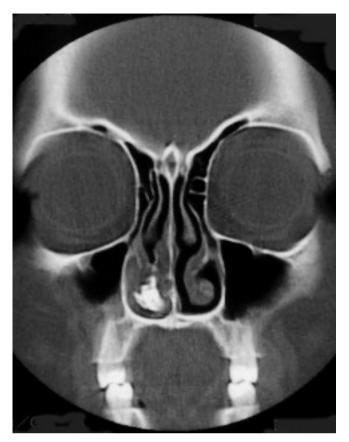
CT scan of patient 2. Tooth in the right nasal cavity.
